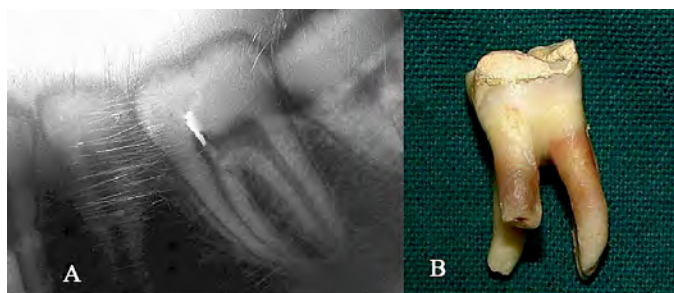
(Left) Periapical radiograph of a mandibular left first molar showing no extra root. (Right) Extracted mandibular right first molar having an extra root radix entomolaris. Case is a 32 year old male.
